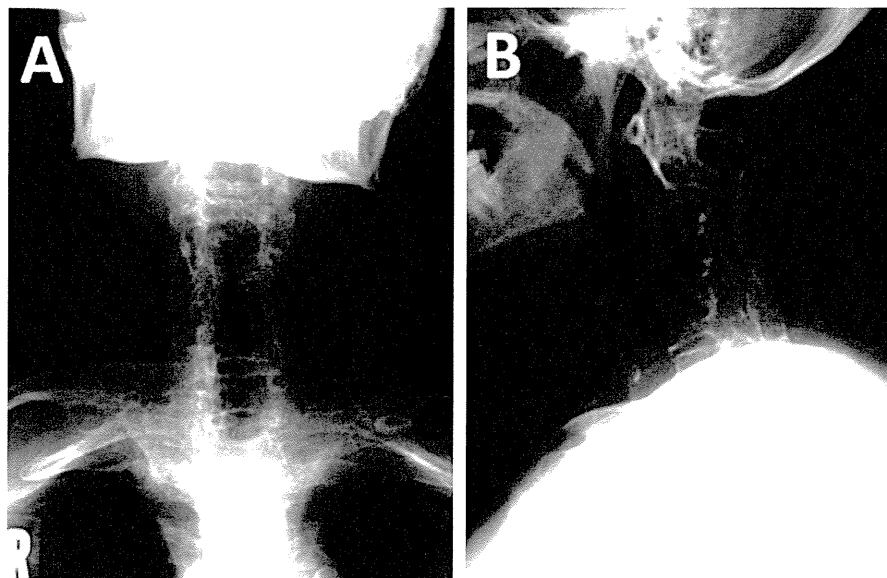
Cervical radiograph 1 year after C3–C7 laminoplasty (A: anterior–posterior view; B: profile view).
